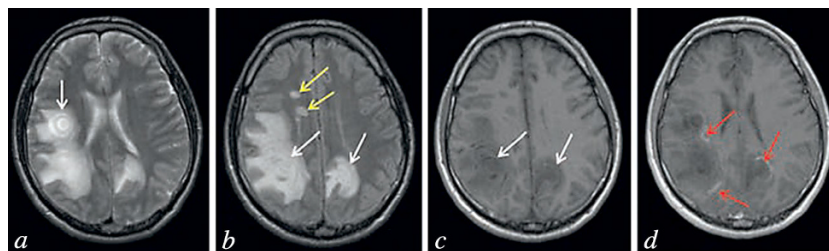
Brain MRI scan with contrast, January 16, 2016, T2 (a), T2 FLAIR (b), T1 (c), and T1 modes after administration of contrast medium (d), axial projection. The white matter of the frontal and parietal lobes of the right hemisphere of the brain and the parietal lobe of the left hemisphere contains three round plaques of heterogeneous structure (alternating annular zones reminiscent of annual growth rings in tree trunks) surrounded by perifocal edema (white arrows). Administration of contrast medium was followed by partial accumulation of medium at the peripheries of these plaques (red arrows). In addition, the white matter of both hemispheres of the brain contain a few typical plaques of demyelination (yellow arrows).
